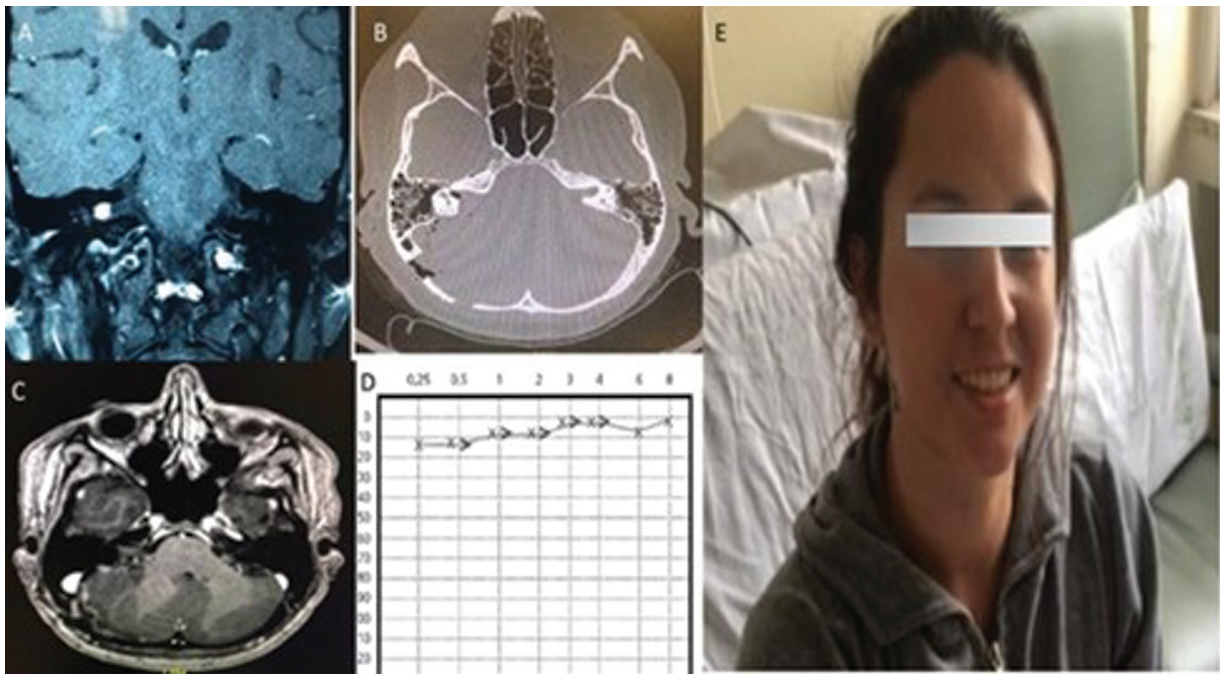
Intraacoustic vestibular schwannoma (grade I). (A) Gadolinium-enhanced T1-weighted sagittal image showing a small lesion within the internal acoustic canal; (B) early postoperative computed tomography (CT) scan showing the opening of the internal acoustic canal; (C) gadolinium-enhanced T1-weighted axial image showing complete tumoral resection; (D) postoperative audiometry showing hearing preservation; (E) postoperative facial motricity preservation.
